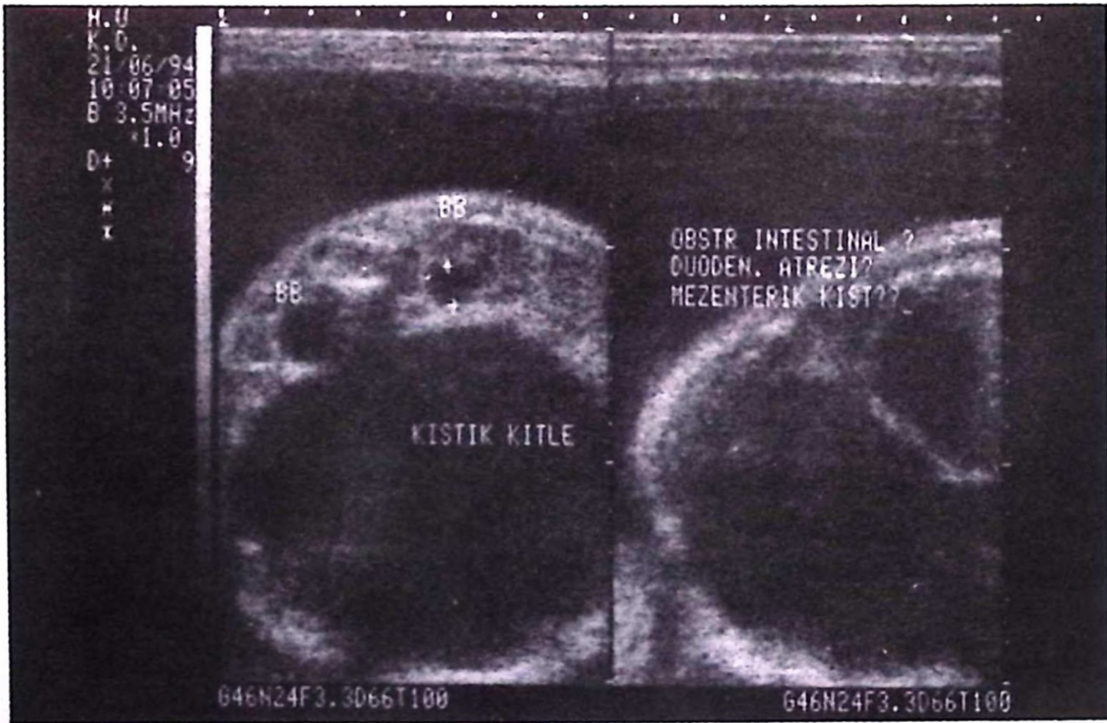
Prenatal ultrasonographic appearance of large cystic structure in the fetal abdomen.
